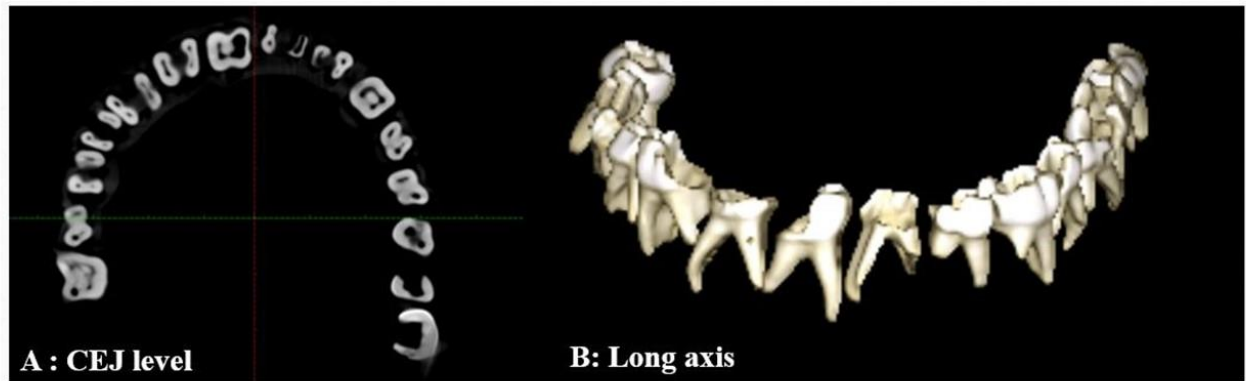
Slice of CBCT image of an arch with mounted teeth
